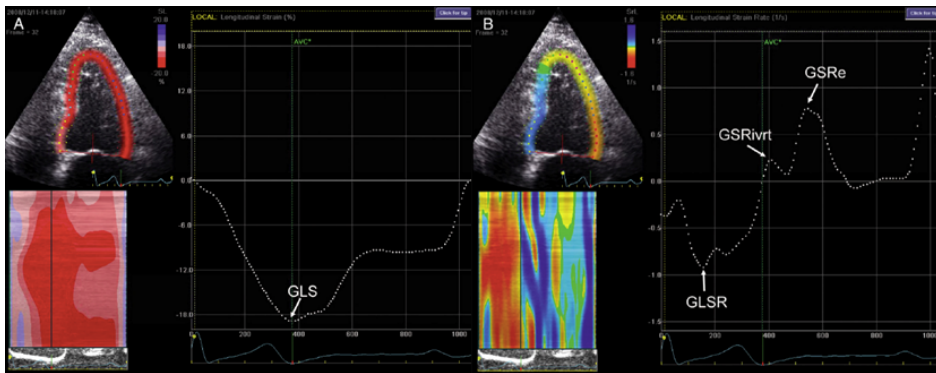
Speckle-tracking echocardiography provides a direct measure of myocardial deformation and can therefore be used to detect subtle abnormalities in LV systolic and diastolic function. Global longitudinal strain and strain rate curves obtained by speckle-tracking analysis from an apical 4-chamber view are shown in panel A and B, respectively.
